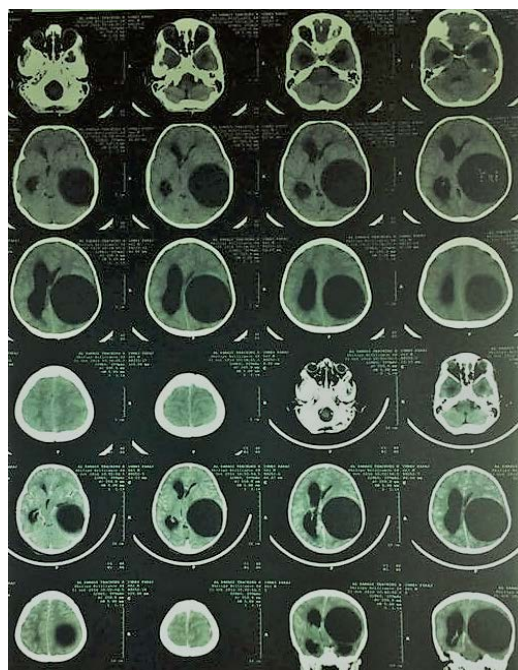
Cerebral CT scan showing cysts of hydatidosis
